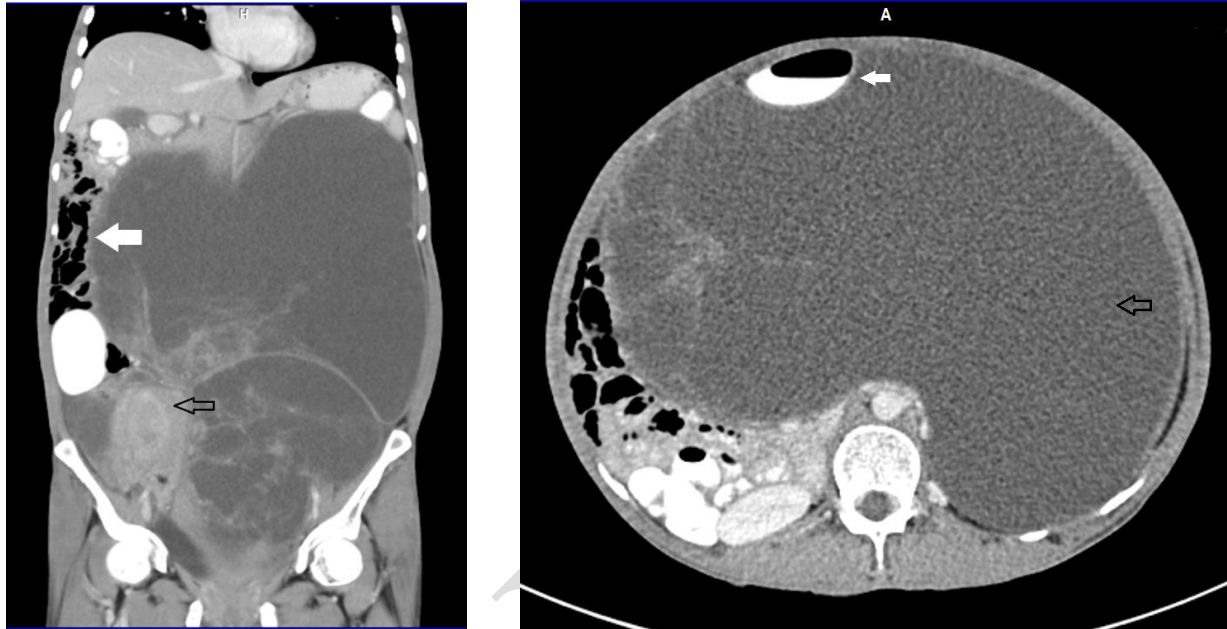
Contrast enhanced CT scan of retroperitoneal leiomyoma shows low attenuation huge mass occupying whole of the abdomen ;[a] black arrow shows uterus and white arrow shows compressed and displaced intestine [b] black arrow shows mass and white arrow shows anteriorly displaced descending colon
